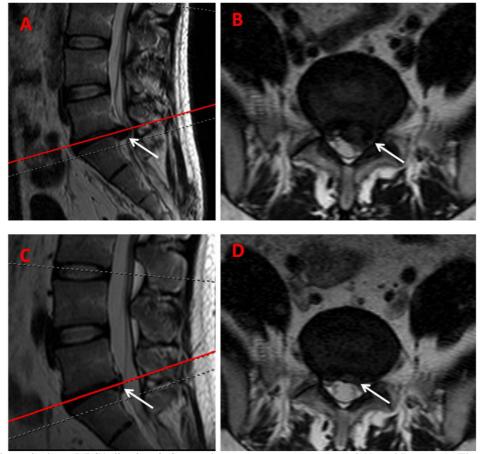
MRI showed a huge L5-S1 disc herniation, and nerve root was compressed (A and B, arrow). The MRI of one year follow up showed the previous huge L5-S1 disc herniation was disappeared (C and D, arrow).
